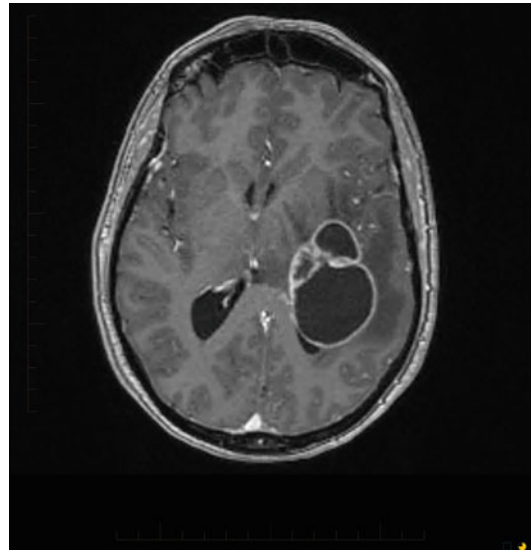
T1-weighted, gadolinium-enhanced MRI showing a left deep-seated cystic glioblastoma
